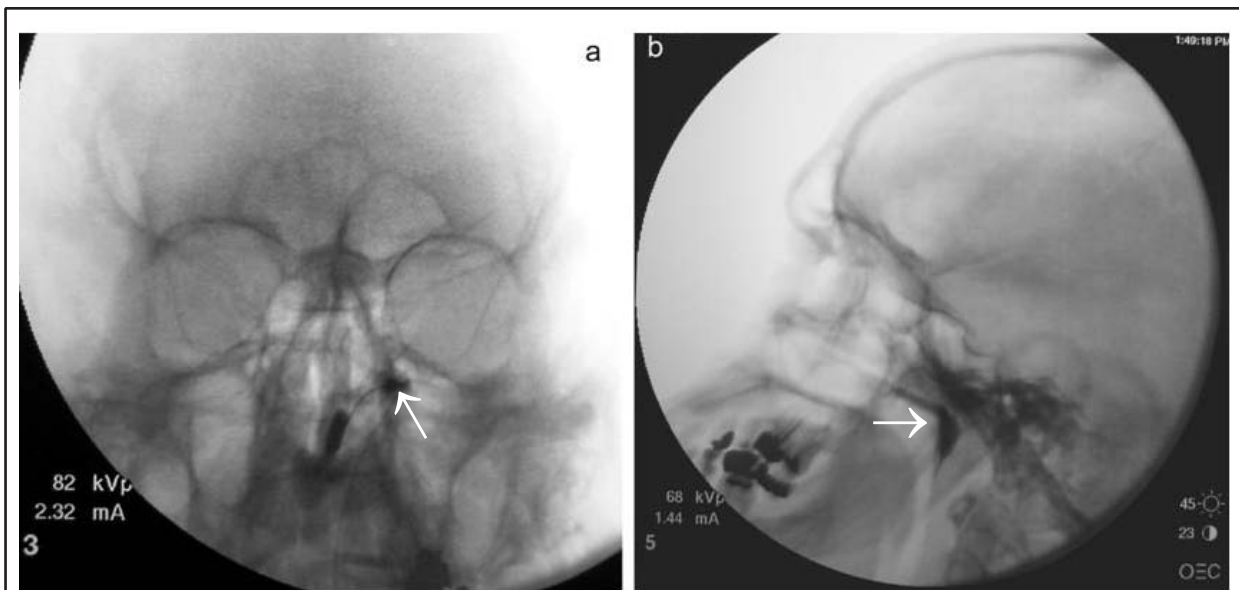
Fluoroscopic views of blocking needle and contrast flow. On the anteroposterior view, the needle tip was located in the left nasal cavity medial to the medial pterygoid plate of the sphenoid bone at the level of the middle concha (arrow) (a). On the lateral view, x-ray contrast flow in the pterygopalatine fossa superoposterior to the left maxilla was shown without vascular uptake (arrow) (b).
